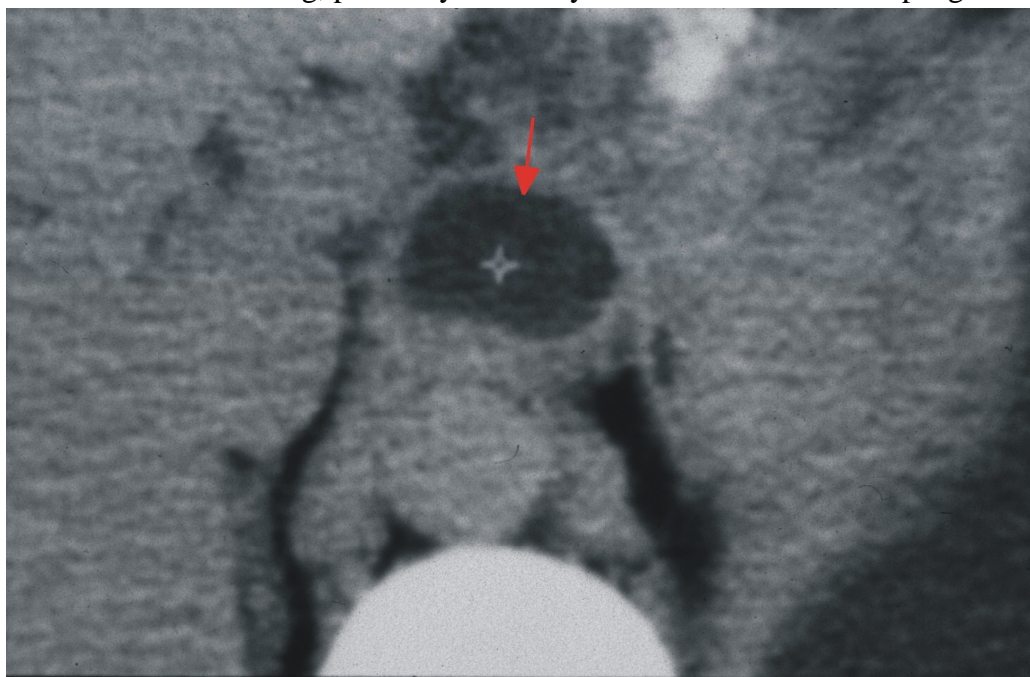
CT -- collection tracking from the body in cranial direction.
